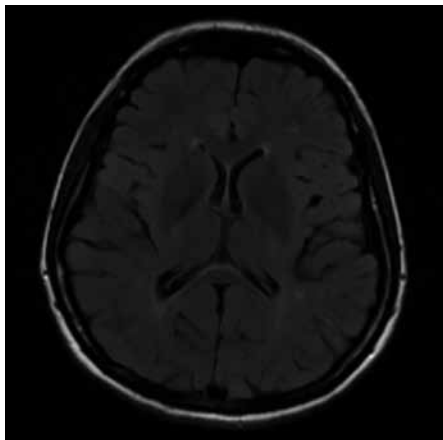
Magnetic resonance imaging T2 fluid-attenuated inversion recovery demonstrating non-specific foci of increased high signal.
